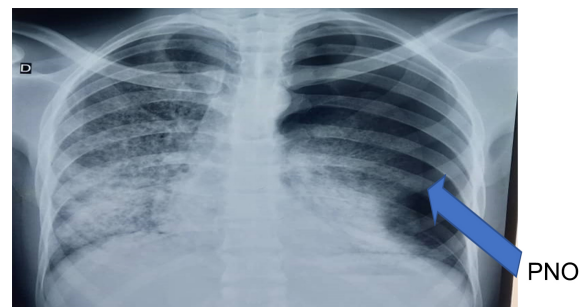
Standard frontal thoracic X-ray image showing a moderately abundant left pneumothorax on MT.
